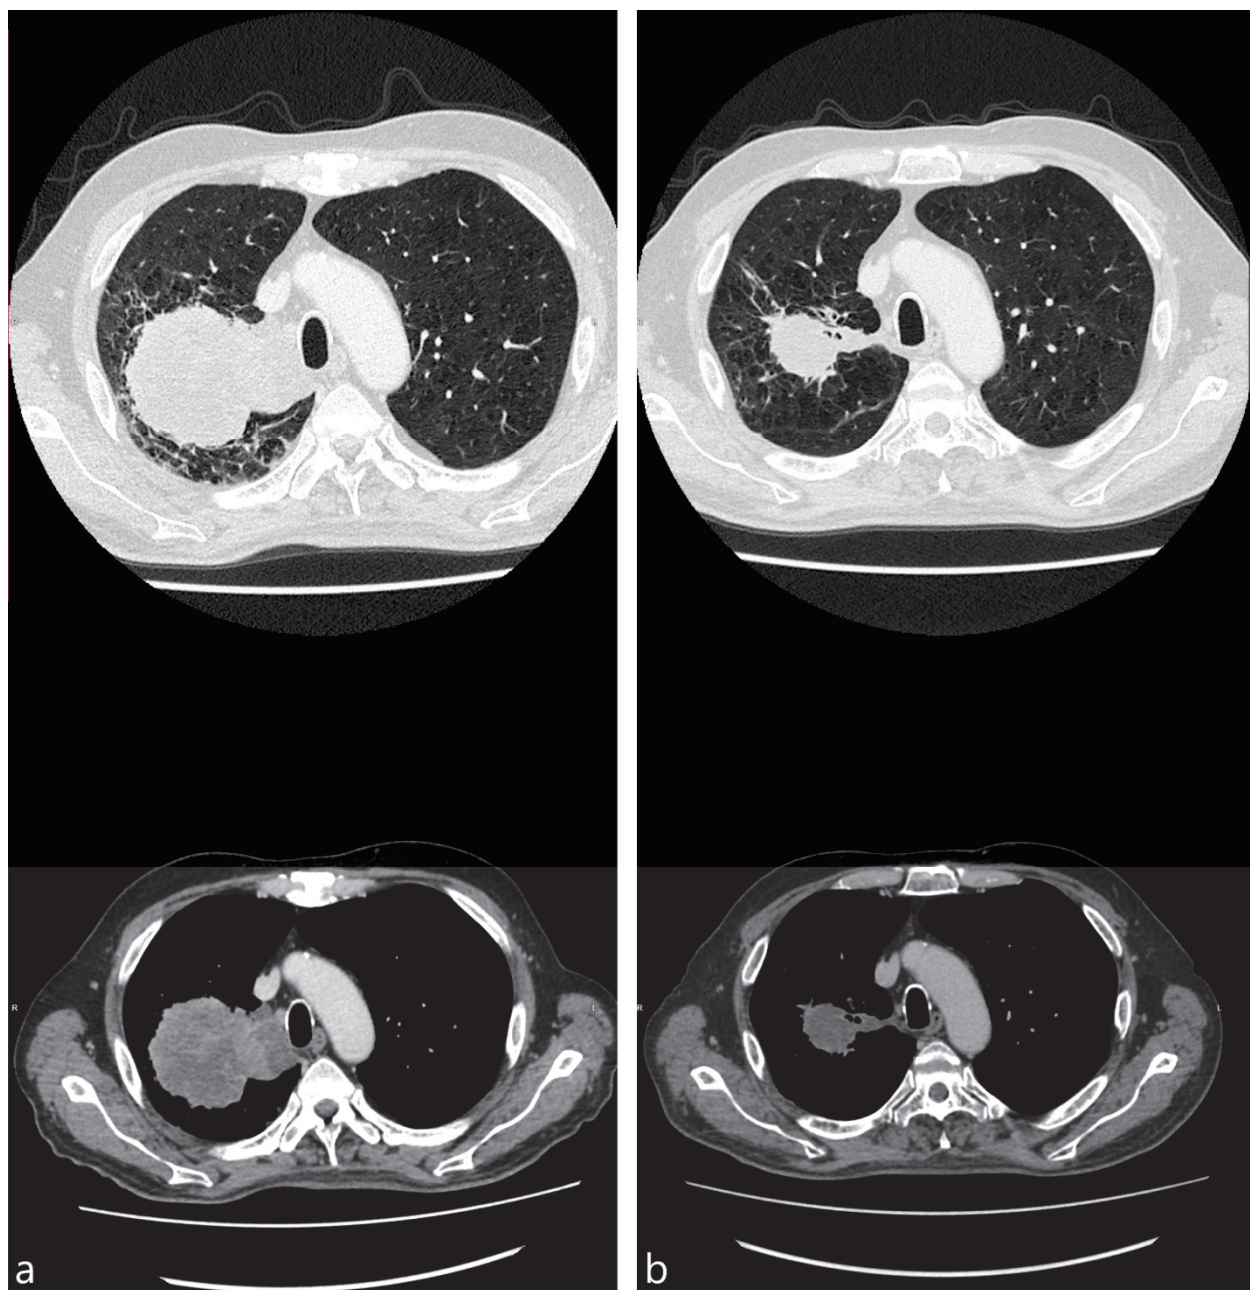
CT images, obtained almost 2 weeks before (a) and 4 weeks after (b) bronchoscopic cryotherapy (65 y.o. male with stage IV adenocarcinoma, PD-L1 expression 20%).
